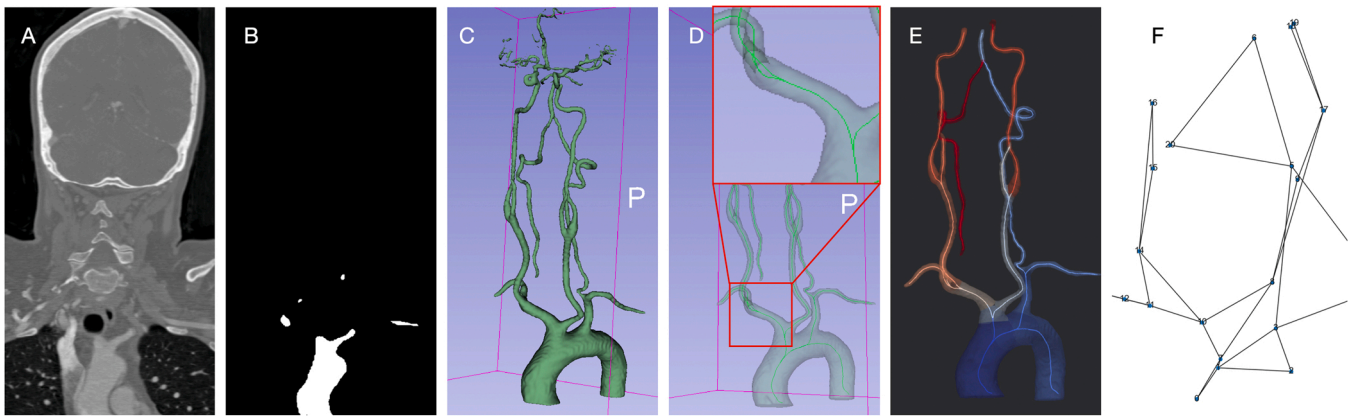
Data processing from the CTA images, through centerline extraction and branching, up to graph generation. (A) Original CTA volume. (B) Binary map output by the segmentation module. (C) Volume model from binary map. (D) Volume model with extracted centerline model. (E) Branched centerline model over clipped surface model output by the centerline extraction module. (F) Graph corresponding to the centerline mesh.
